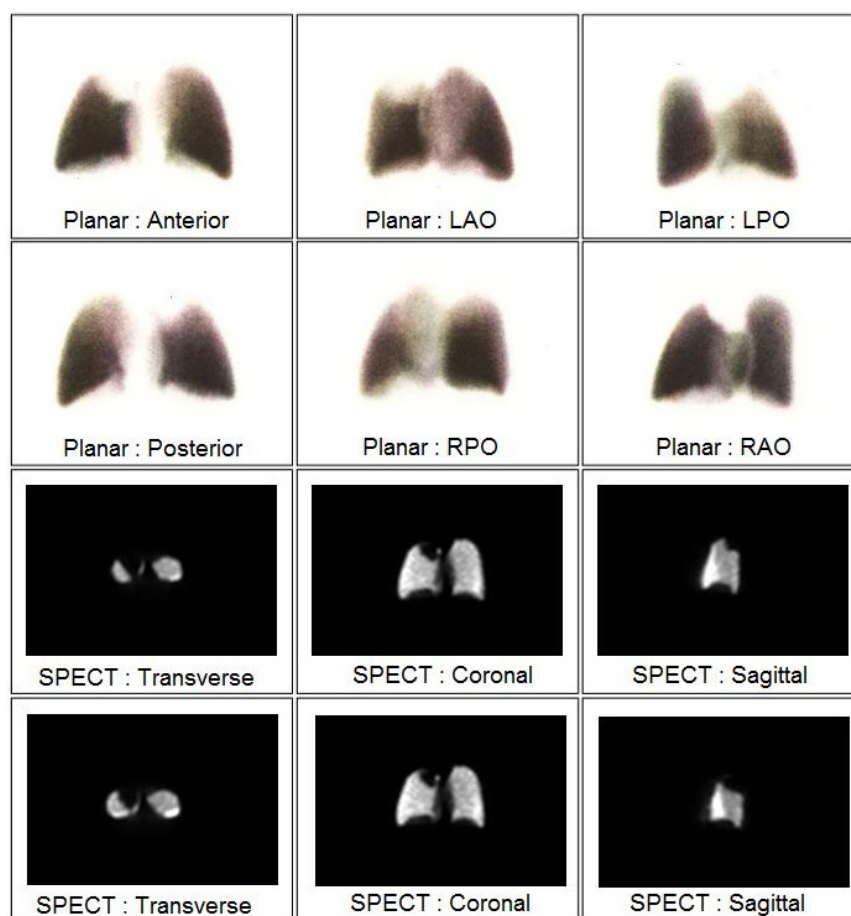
Planar and SPECT images of a perfusion defect within the apical segment of the right upper lobe.
